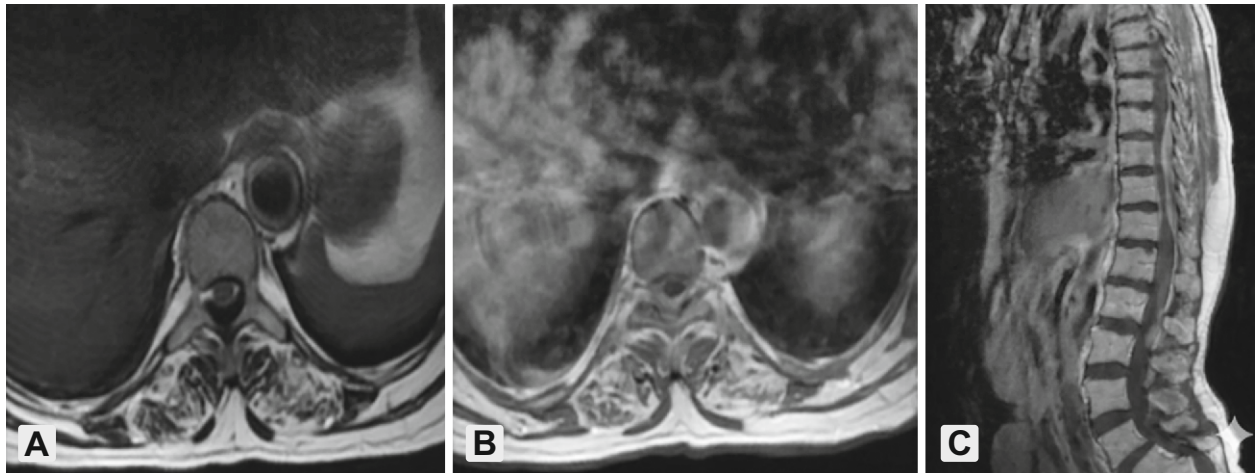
Axial T2 (a), T1 post-contrast (b), and sagittal post-contrast (c) magnetic resonance images (MRI) of the dorsolumbar spine showing a sheet-like, homogeneously enhancing extradural lesion almost circumferentially encasing the spinal cord, displacing and flattening it, and extending from T8 to T11.
